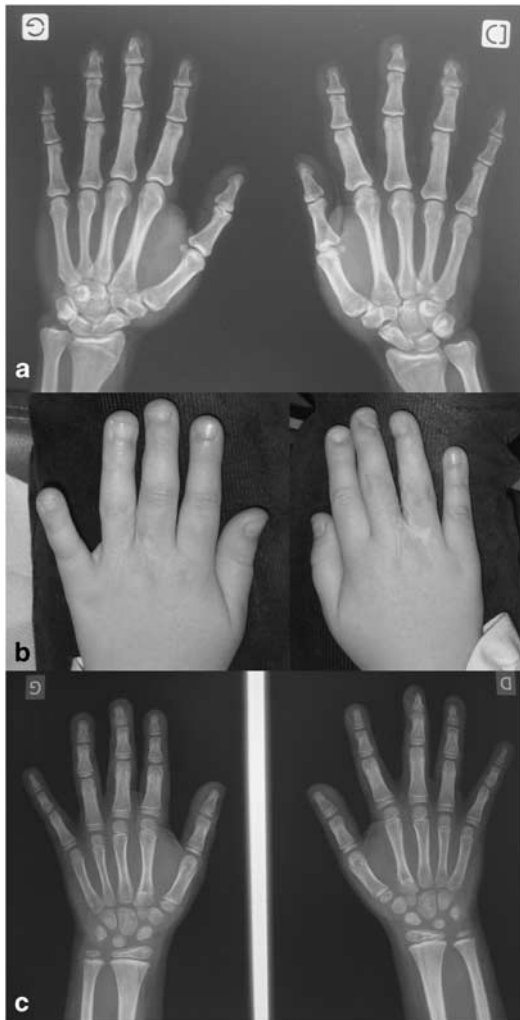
(a) Normal hands X-rays of the affected father. (b) Hands of the daughter after surgery. Note scars after surgery for 3–4 fingers' skin syndactyly. (c) Normal hands X-rays of the affected daughter.
